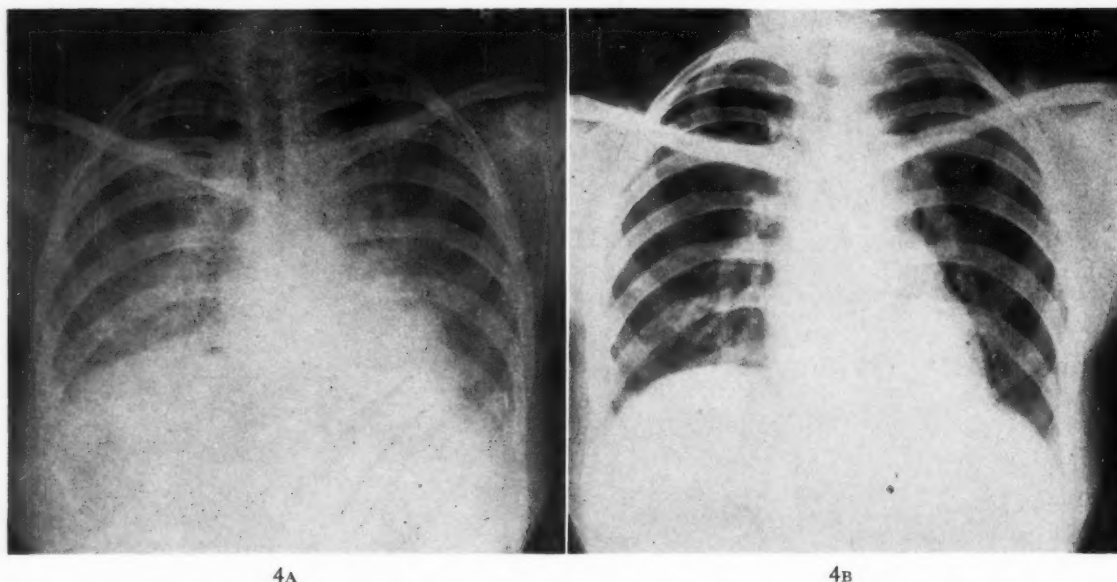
A, x-ray of the chest of patient G. M., Case III, with pulmonary insufficiency of unknown etiology before treatment with ACTH; B, chest x-ray of same patient after treatment with ACTH.
